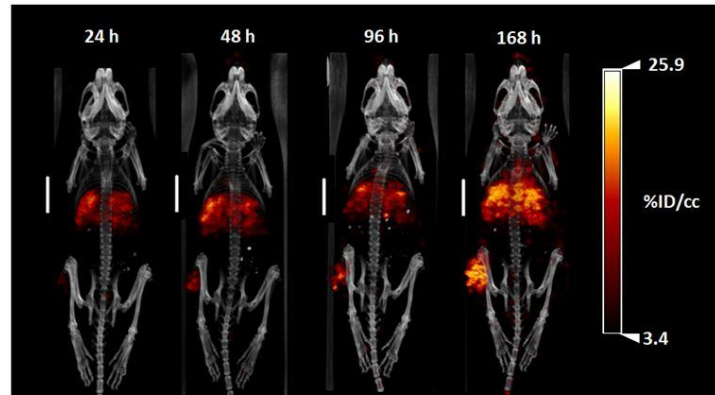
SPECT/CT visualizes [¹⁷⁷Lu]Lu-DOTA-RW03 tumor uptake over the first week of treatment.
